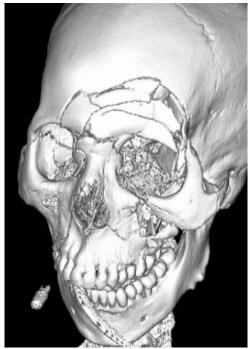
Head CT 3D reformatting
